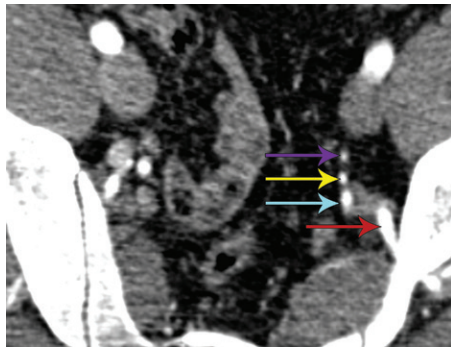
Axial CT angiogram at the level of the greater sciatic foramen shows localization and visualization of the four major pelvic arteries. From anterior to posterior, they are the obturator (purple arrow), internal pudendal (yellow arrow), inferior gluteal (blue arrow), and superior gluteal (red arrow) arteries.
